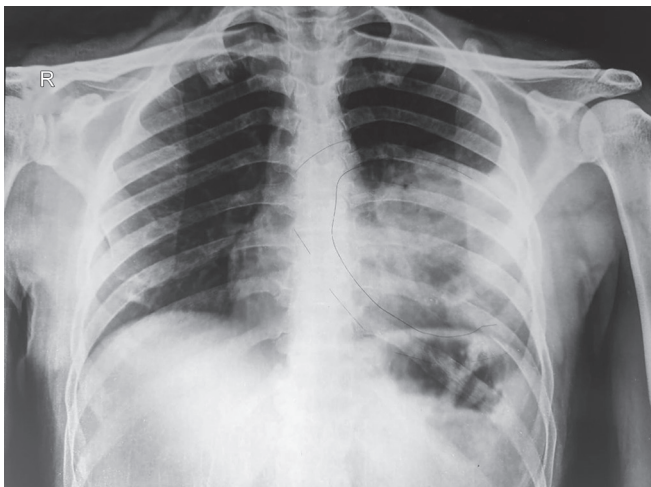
Plain chest roentgenogram, which revealed airspace opacification in the left middle zone
